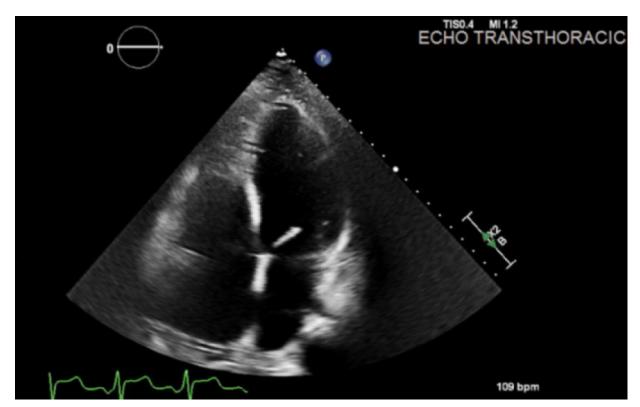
Transthoracic echocardiogram shows mildly dilated left ventricle with an ejection fraction of 20% to 24%, end-diastolic volume index of 177 mL, mild to moderate mitral regurgitation, and a small pericardial effusion.
